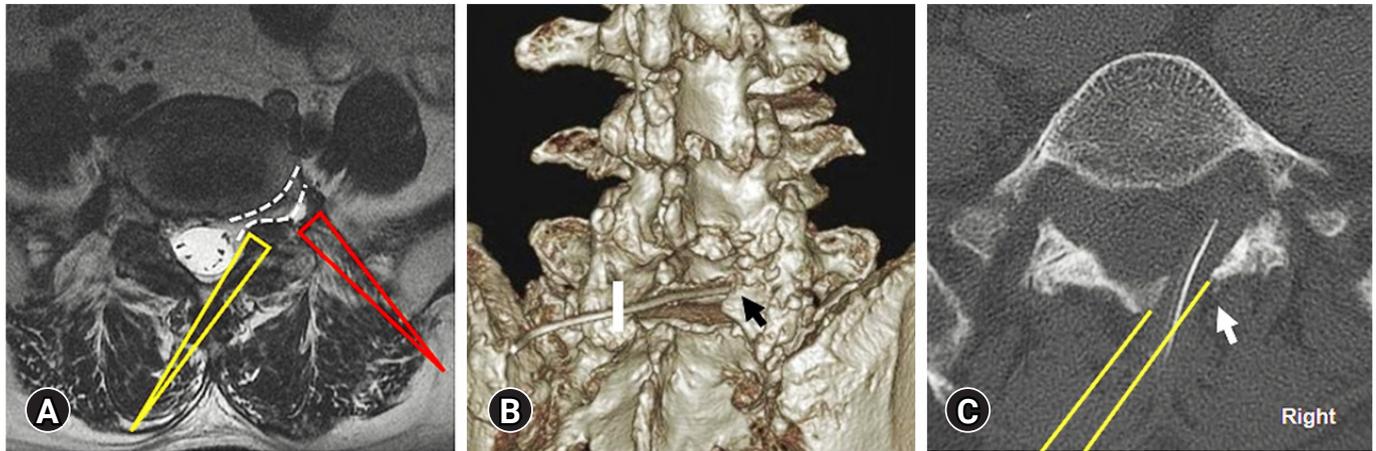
Interlaminar contralateral endoscopic lumbar foraminotomy for the removal of the symptomatic extraforaminal juxtafacet cyst at the L5-S1 level. (A) The endoscopic system moves nearly parallel to the exiting nerve root and accesses the foraminal and extraforaminal region. The view of the entire nerve root in the foraminal to the extraforaminal region obtained using a 30° endoscope without nerve root retraction (long yellow triangle). Endoscopic transforaminal approach for the extraforaminal cyst (long red triangle). (B) Postoperative 3D reconstructed computed tomography (CT) showing the contralateral (right) partial laminotomy (black arrow), and endoscopic approach was started from the left side skin entry point at the medial facet joint line (white bold line). (C) Axial CT image showing the right contralateral partial laminotomy site (white arrow) and a tract used for endoscopic approach (yellow double lines).
